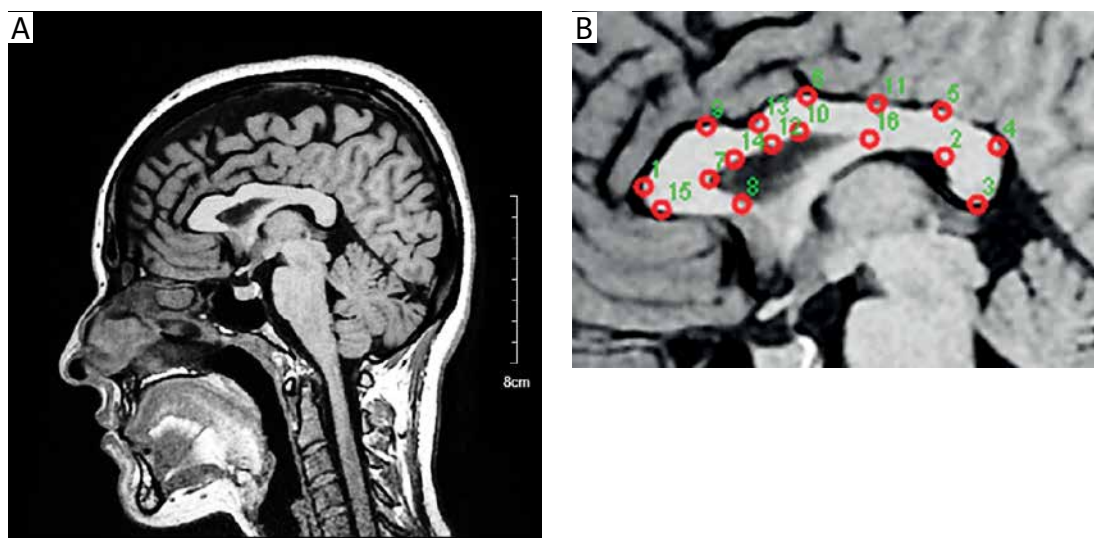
A) A cross-sectional image selected from the MRI examination and B) in this image, the CC is marked with standard anatomical landmarks
